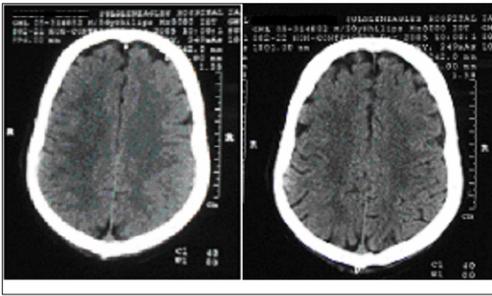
Cranial CT scan showing improvement in cerebral oedema. (pre-MARS dialysis, left; and post-MARS dialysis, right).
